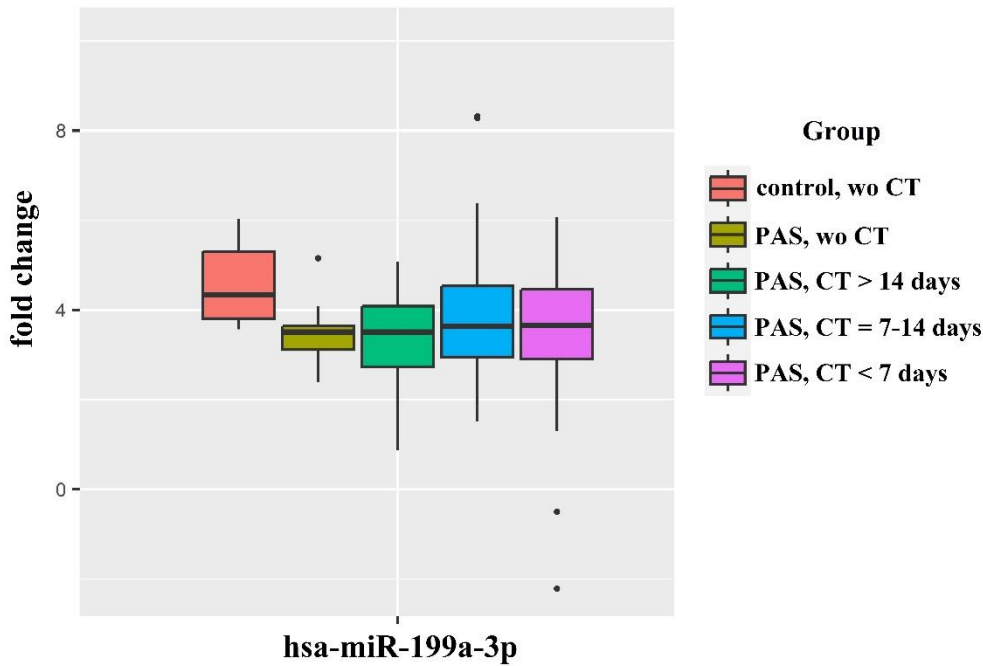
Dynamics of changes in hsa-miR-199a-3p levels in the blood plasma of newborns compared to their mothers' blood plasma, with and without PAS, depending on the timing of antenatal corticosteroid therapy (CT).
